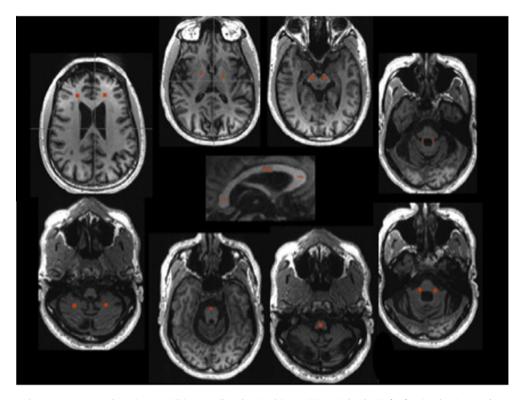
Region of interest placement on a sample patient's axial (surround) and sagittal (center) T1-weighted MRI for fractional anisotropy/apparent diffusion coefficient analysis.
